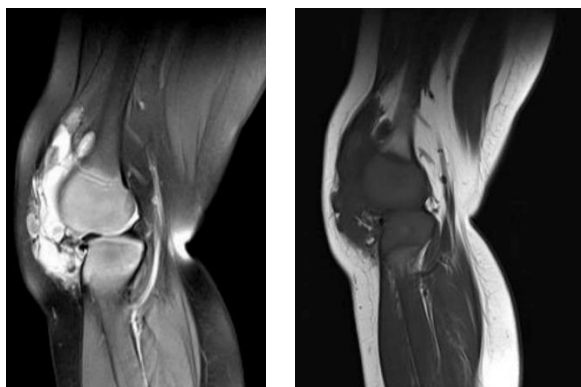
(A) MRI T2-weighted sequences (a) and T1-weighted sequences (B) showing high intensity mass in retroapatellar and suprapatellar regions
